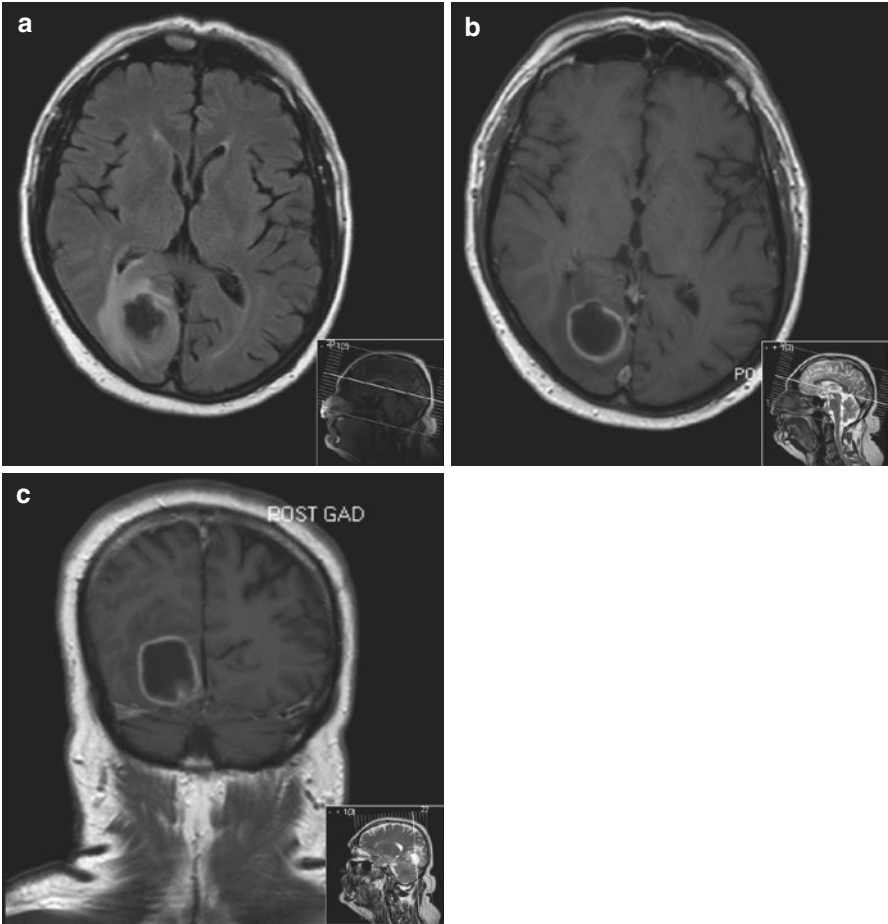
MRI scan of brain showing the lesion with central necrosis and ring enhancement. There is surrounding vasogenic edema
